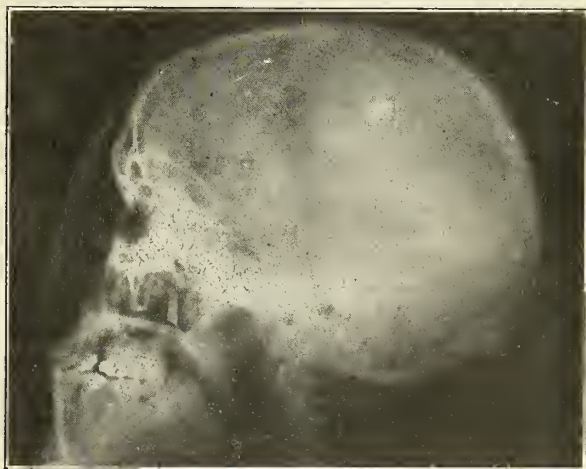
(Case A374381). Lateral roentgenogram showing splinter of glass in the right zygomatic region.
